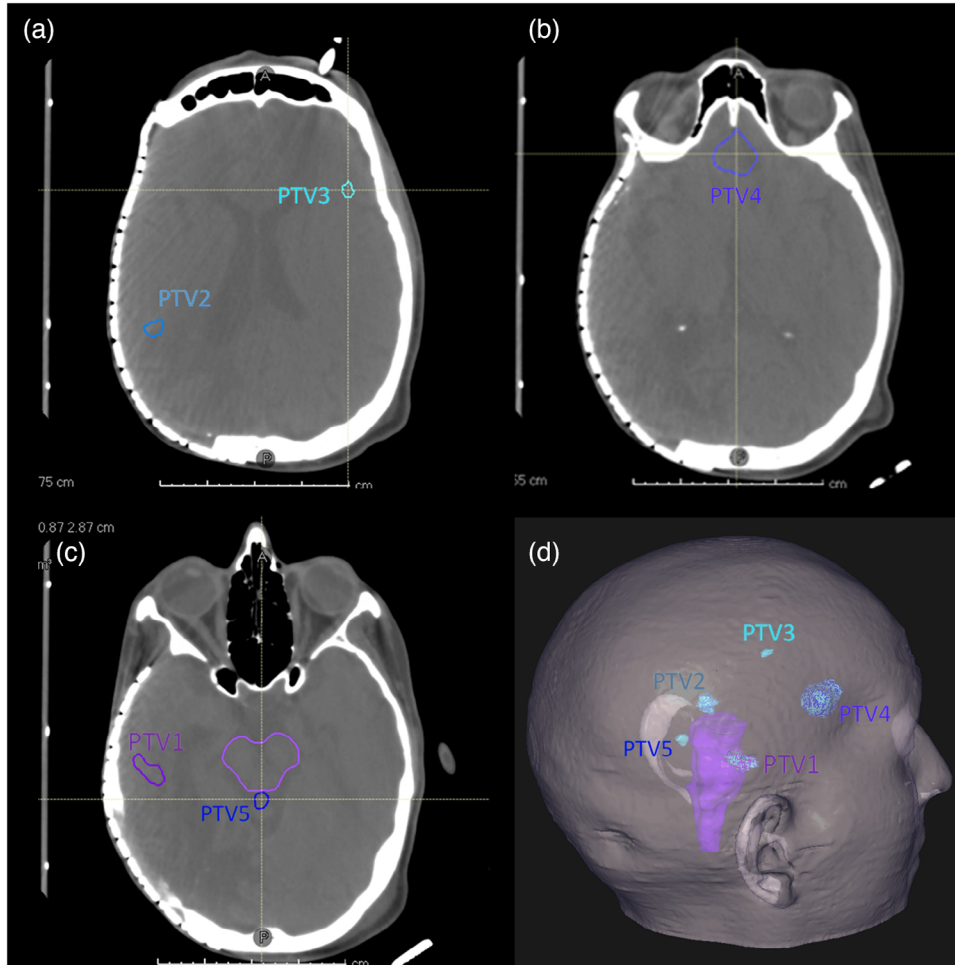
PTV locations relative to patient anatomy from patient CT scan for (a) PTV2 and 3, (b) PTV4 and (c) PTV1 and 5, with (d) showing a 3D render of all targets shown in blue, with the brainstem in purple.
